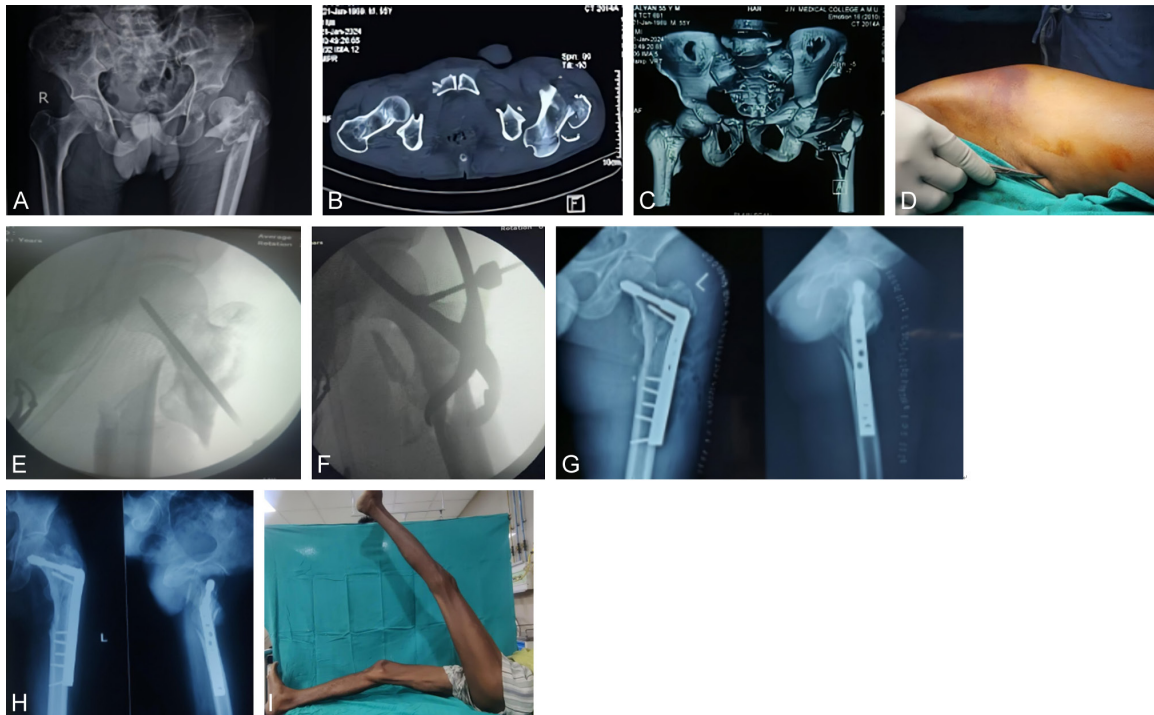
A 55-year male presented after injury to left hip following MVA. X-ray showed hip dislocation with ipsilateral IT fracture (A); CT scan with 3D reconstruction revealed posterior hip dislocation with IT fracture on left side. Note the medial spike of the proximal fragment [arrow] (B, C); the medial spike was marked using haemostat intra-operatively (D); IITV picture after reduction of hip joint (E); the IT fracture was reduced using bone clamp and later fixed with DCS (F); x-ray at 6 month and 1 year follow-up (G, H); functional outcome at 1 year follow-up (I) [MVA - Motor vehicle accident, IT - Intertrochanteric, IITV - Image intensifier TV, DCS - Dynamic condylar screw].
